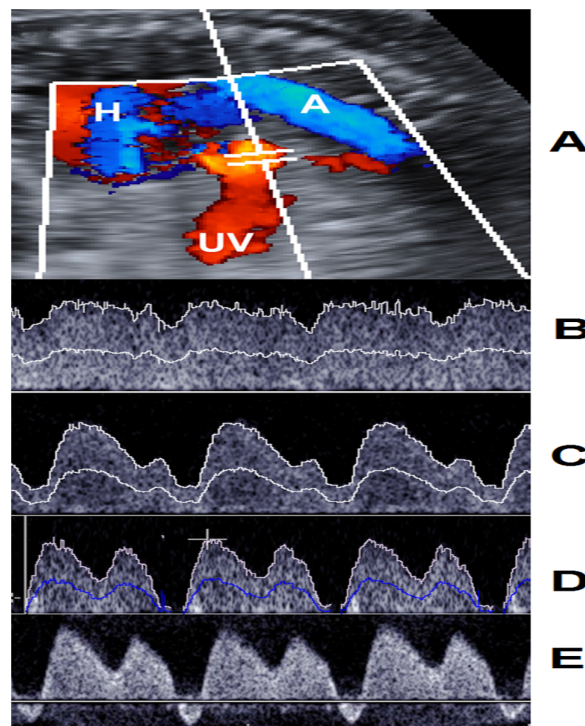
A, Site of insonation of the DV with color Doppler. Progressive waveform patterns with advancing severity are shown: B, normal DV waveform, C, increased impedance to flow, D, absent enddiastolic flow, and E, reversed end-diastolic flow. A, descendent aorta; DV, ductus venosus; H, heart; UV, umbilical vein.
